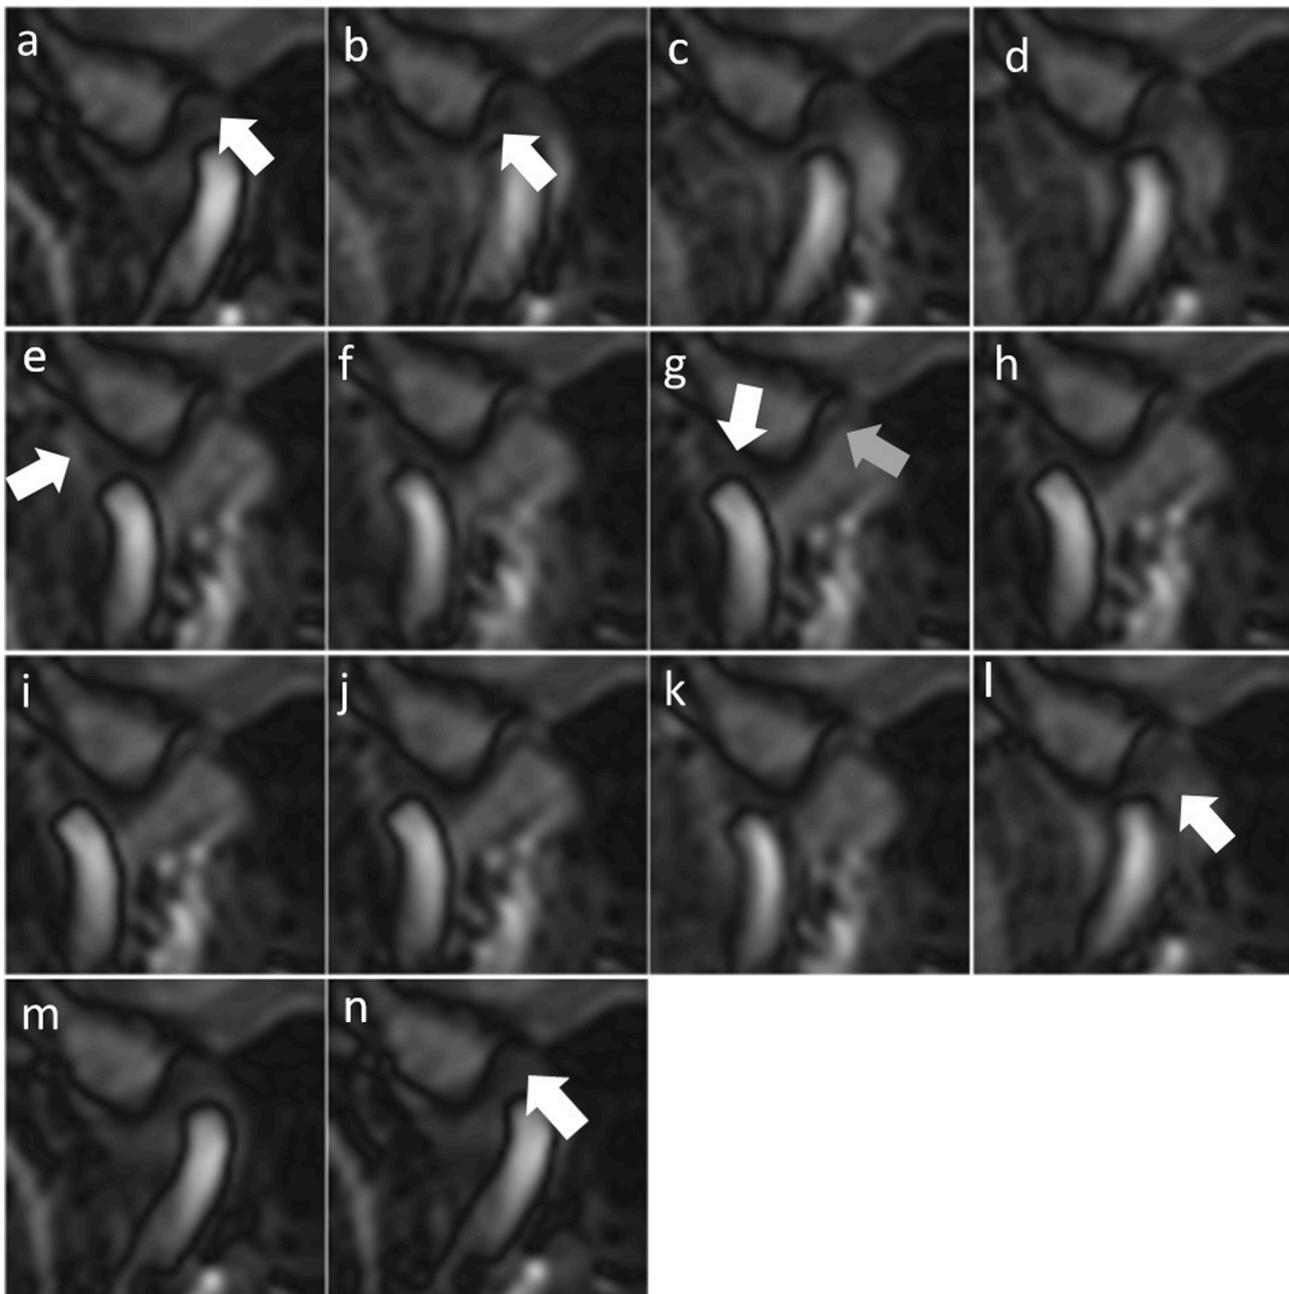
Dynamic MRI sequences of the patient from Fig. 1. The dynamic sequence starts in closed mouth position and slightly anterior positioned disc (a, white arrow). During mouth opening (a-g) the condyle translates to its physiological position below the disc (b and e, white arrows) until complete open mouth position is reached with the condyle being anterior of the tuberculum (g). The posterior ligament (gray arrow in g) of the disc is attached to the temporal bone, stretched at maximum mouth opening and prevents the disc (white arrow in g) from gliding further anterior. During mouth closing the condyle translates below the disc (white arrows in j and l) back into the fossa (h-m) until closed mouth position is reached and the disc is slightly anterior positioned (n, white arrow).
